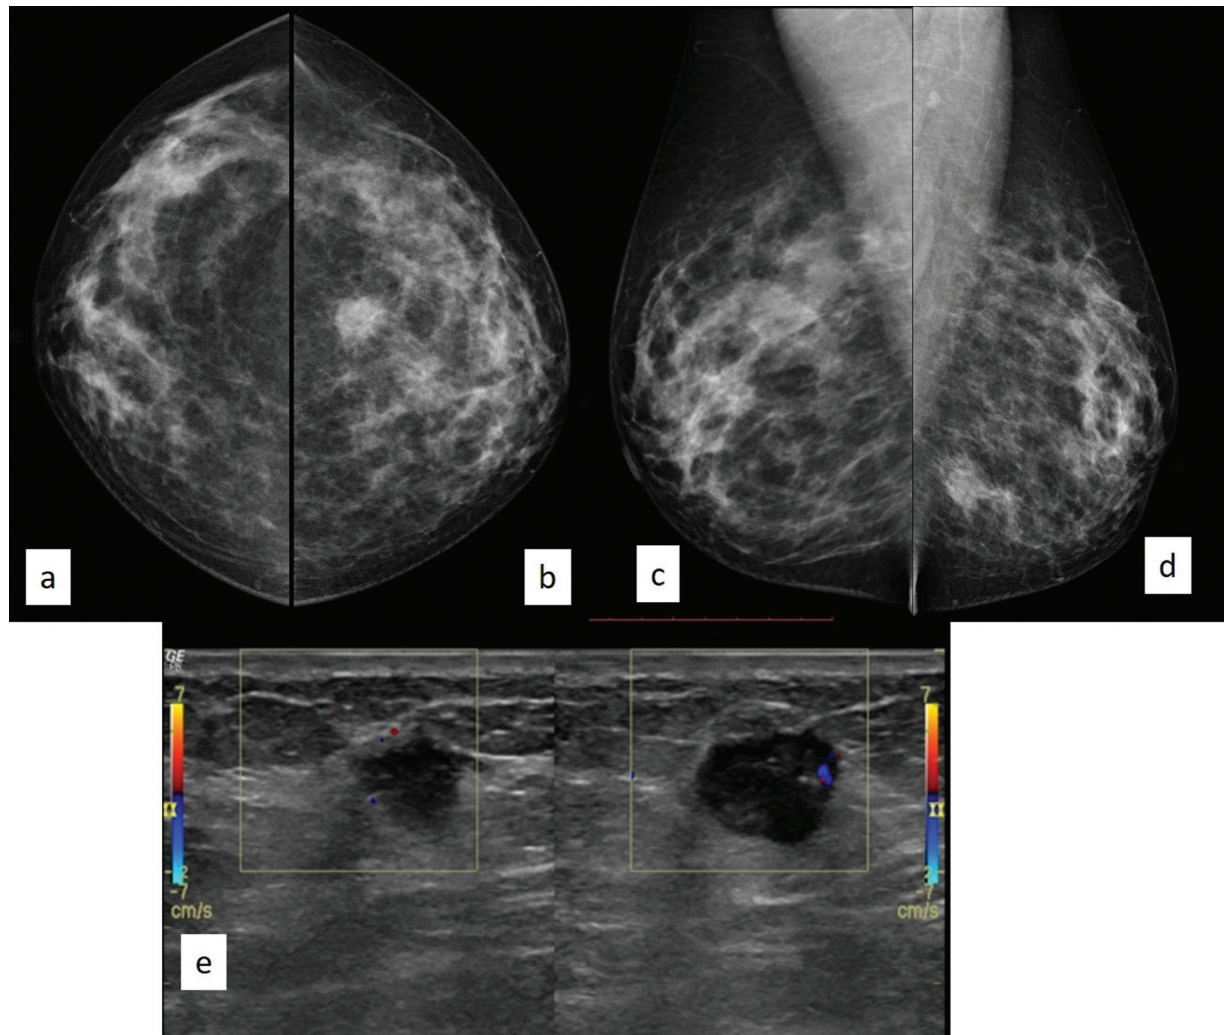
A 45-year-old woman having a family history of breast carcinoma with duct cell carcinoma in situ of the left breast. (a–d) Mammography shows the presence of an oval high-density mass lesion with spiculated margins in the outer lower quadrant of left breast. (e) On ultrasound, a hypoechoic mass lesion with edge shadowing and moderate vascularity was present.
